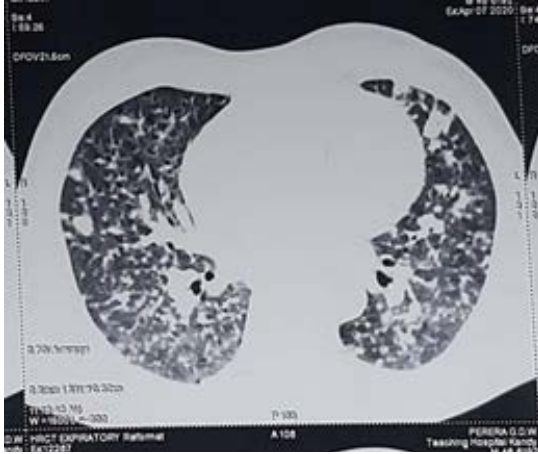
The HRCT chest following the treatment of AOSD
